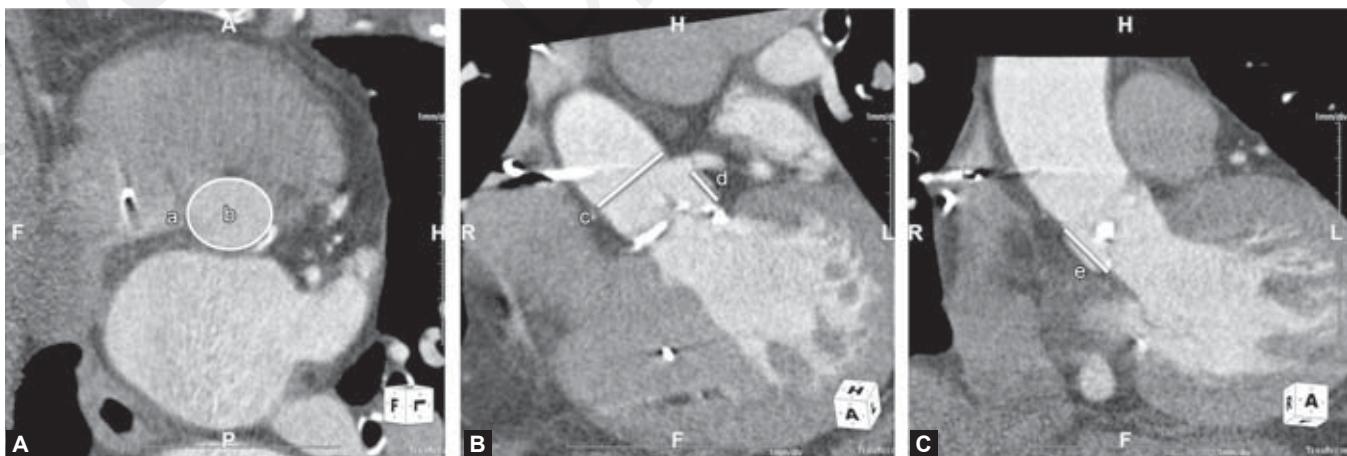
Multidetector computed tomography imaging for procedural planning. A, Perimeter-derived area of annulus; B, Estimated area of annulus; C, Diameter at sinotubular junction; D, Height of coronary ostia from aortic annulus; E, Sinus height, measured from aortic annulus.
